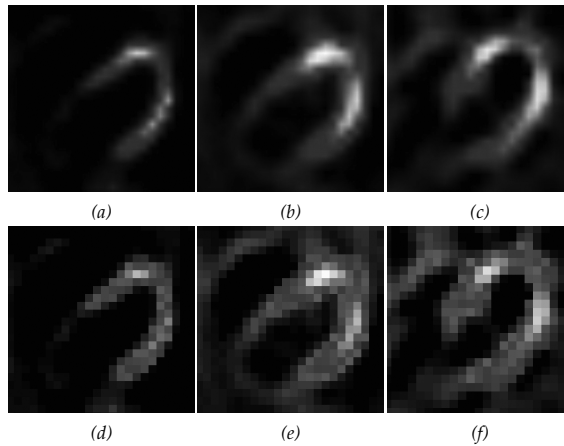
Interpolated (top) and original (bottom) axial views of a virtual (a-b, d-e) and a clinical (c,f) gSPECT study. They were reconstructed by means of OSEM (a,d) and FBP (b-c, e-f). FBP= Filtered Back-projection; OSEM= Ordered-subset Expectation Maximization. (See color insert)
